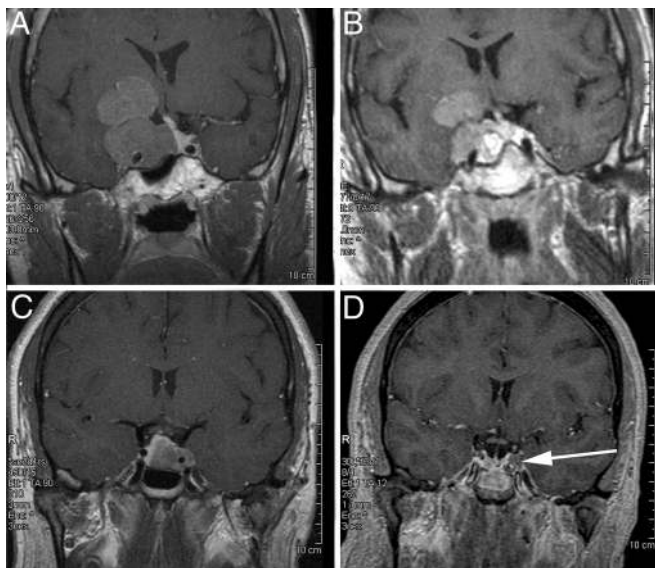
Biochemical remission in spite of residual tumor. A, Preoperative T1-weighted contrasted coronal image of a patient with a Knosp 4 tumor. B, Postoperative T1-weighted contrasted coronal image of the same patient with clear residual tumor. C, Preoperative T1-weighted contrasted coronal image of a patient with a Knosp 4 tumor. D, Postoperative T1-weighted contrasted coronal image of the same patient revealing residual hypointense tumor (indicated by the arrow). Both patients attained biochemical remission according to the 2010 consensus criteria.
